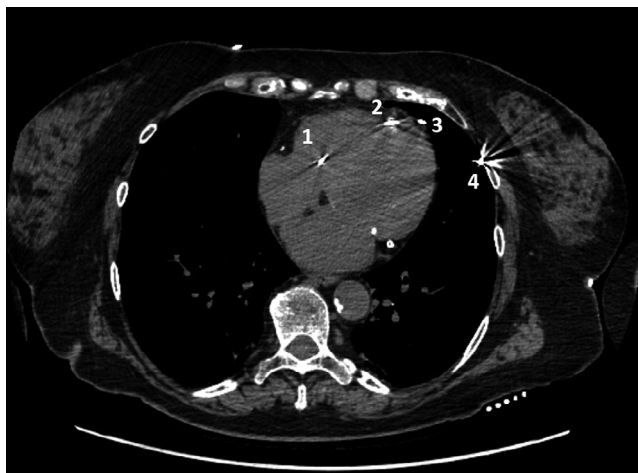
Thoracic computed tomography scan. The radiological scan clearly shows the ventricular lead course from the right ventricle (1) to the left chest wall (4) in this patient. Perforation of both the interventricular septum (2) and the left ventricular free wall (3) are well evident, posing the non-surgical lead extraction at an exceedingly high procedural risk. Computed tomography scan should therefore be regarded as the gold standard for the strategical management of this complication
